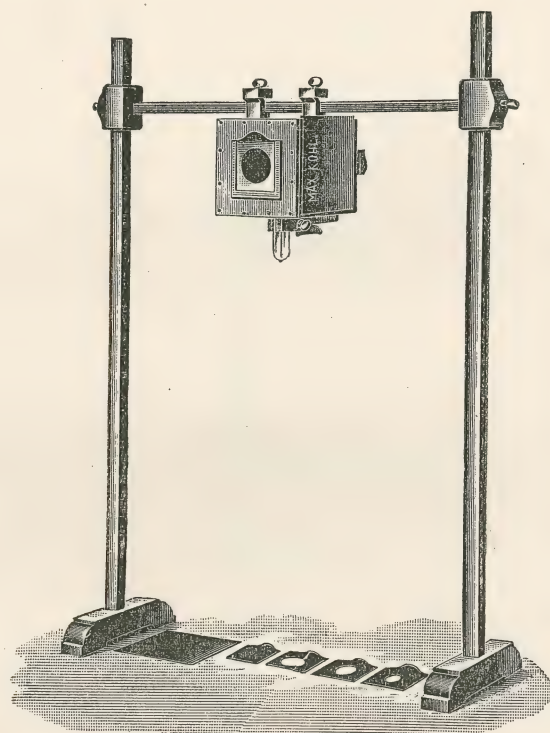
Dr. Levy-Dorn's "Protection Box" tube-holder with series of six lead diaphragms of assorted sizes. It is adjustable on the standard, and when the tube is used in the box it excludes all general light and allows only the X-rays that come through the window of the selected diaphragm to reach the patient. It is especially designed to avoid ill-effects from exposures to X-rays. It is lined with lead and is also fitted with an aluminum screen. In addition to the protection of patients it is also useful to regular workers in this field who are exposed several hours daily. Such a box will preserve their hands and eyes from injury.
